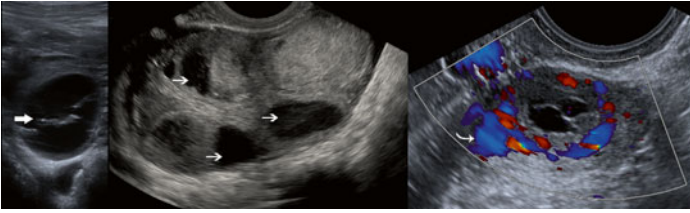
Transverse US and Doppler US of a complex ovarian cyst with large central septation (*large white arrow*), an ovary with numerous large thin-walled theca lutein cysts (*white arrows*) in follicular hyperstimulation, and a normal corpus luteum cyst surrounded by its pathognomic “ring of fire” (*curved white arrow*) of peripheral increased vascularity.
